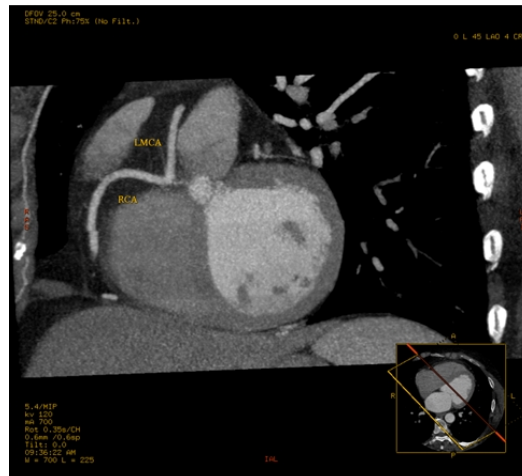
CT angiogram showing shared ostium between LMCA and RCA.
